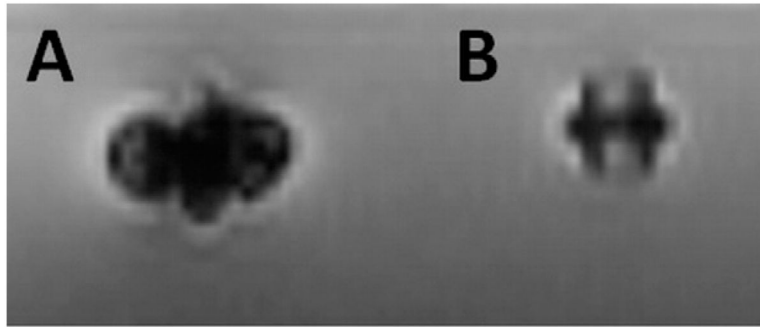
Ex Vivo MRI of Muscular VSD Occluder
